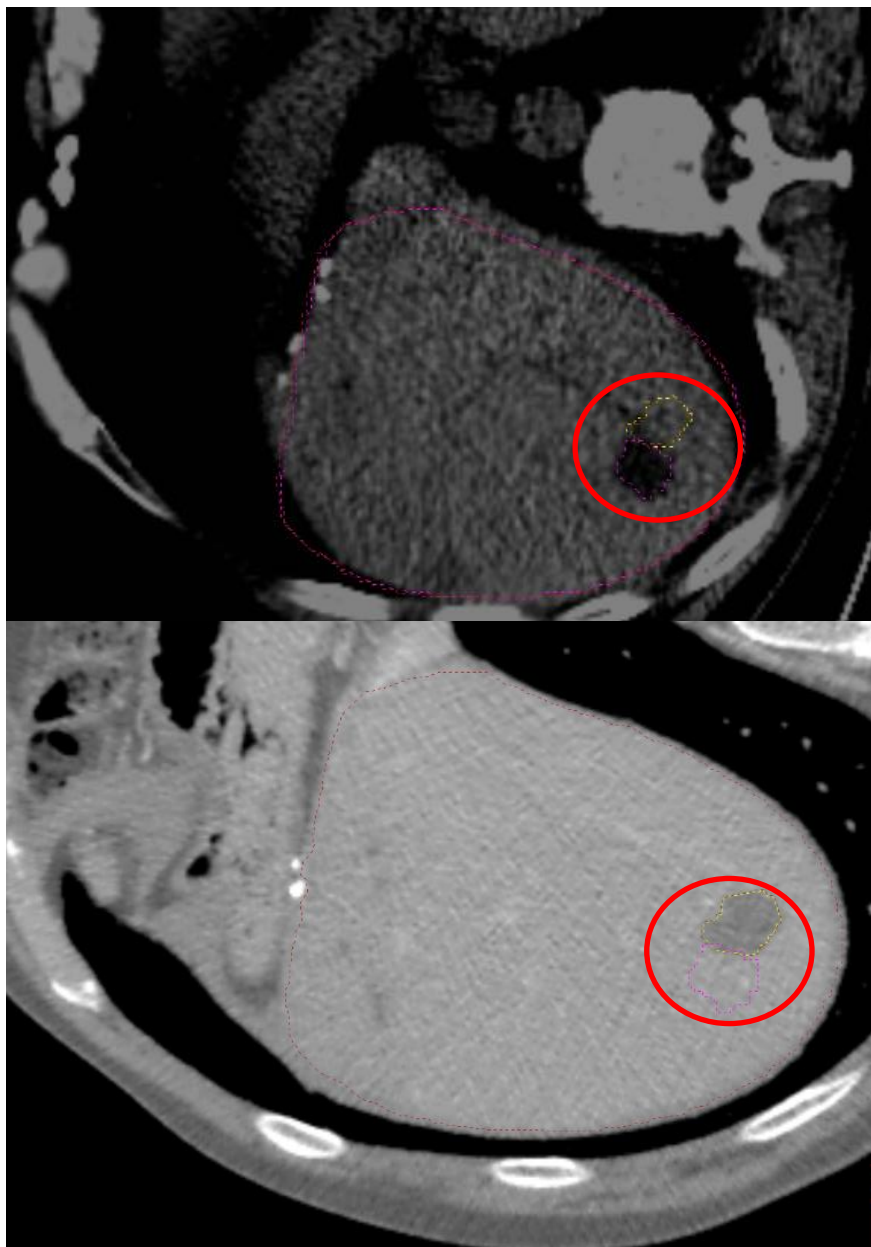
The liver and a cyst segmented on the diagnostic CT (pink and yellow lines) projected over the low-dose CT after registration of the two scans (left), the cyst segmented on the low-dose CT projected over the diagnostic CT is seen on the right side. Even though the liver contours are quite similar after registration, it is observed that the segmented cyst contours do not overlap between the two scans.
